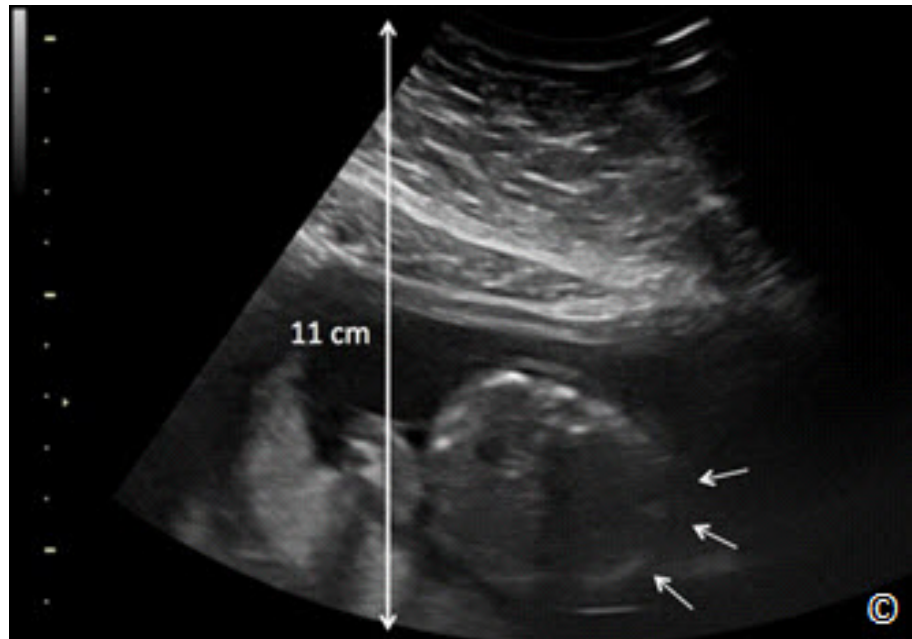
Ultrasound image of the fetal abdomen at a depth of 11 cm in an obese pregnant woman. Note the sub-optimal resolution of the right lateral fetal abdomen (small arrows).
